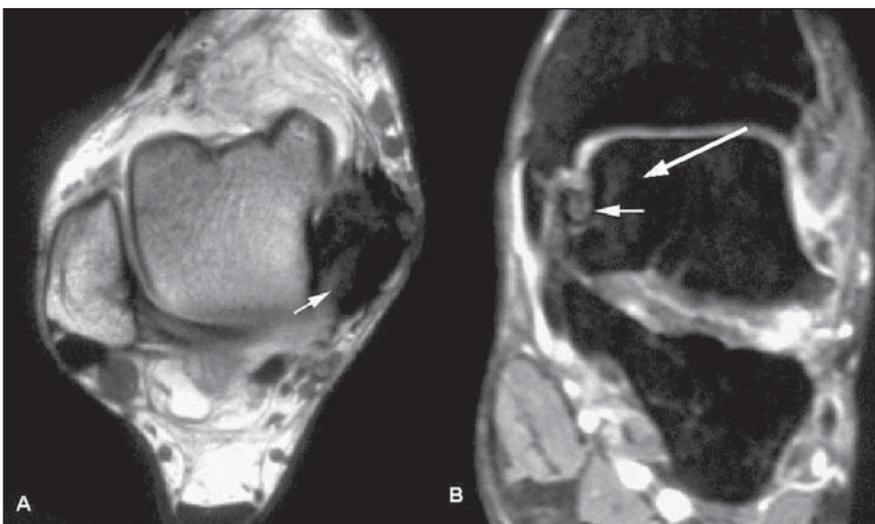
Axial T1-weighted (A) and coronal, fat-suppressed proton-density weighted (B) images demonstrating isointense tissue in the posteromedial region of the ankle (short arrows) and irregularity on the posteromedial talar surface, with subtle corresponding bone marrow edema (long arrow), characterizing posteromedial ankle impingement.
